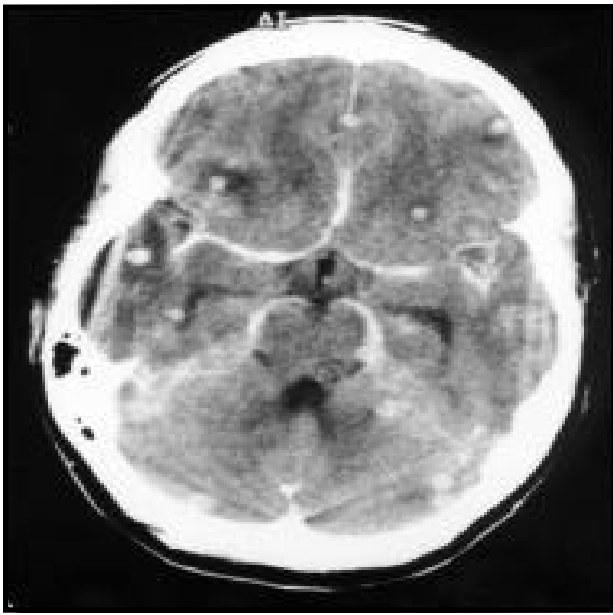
Post intravenous contrast axial CT at the level of the cerebellum.
